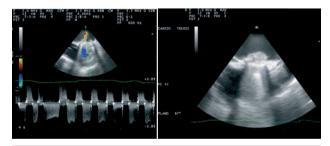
Transesophageal echo showing thrombus protruding into the left atrium (LA). Mild mitral regurgitation
